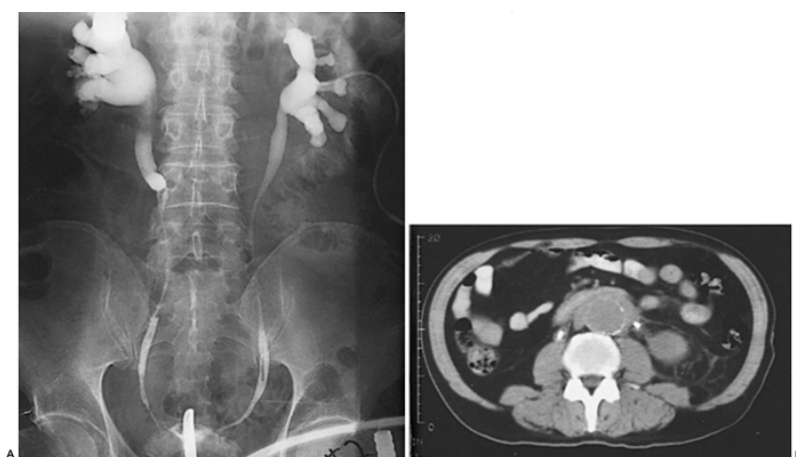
A: Bilateral retrograde pyelograms of a 61-year-old man presenting with anuria. Note bilateral hydronephrosis and medial deviation and narrowing of both ureters. B: Computed tomography scan in same patient following establishment of urinary tract drainage by bilateral double-J stents. Demonstrated is retroperitoneal fibrosis surrounding a calcified inflammatory aortic aneurysm.
